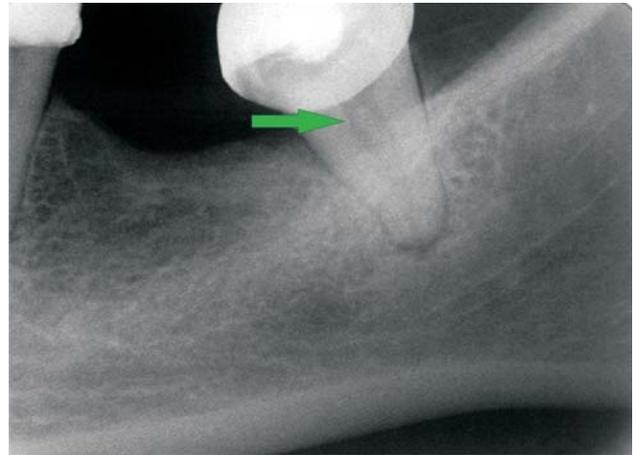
Retro-alveolar radiography of a 42-year-old patient with a large-sized denticle on the level of the 3.8 molar. It is also noticed the existence of a profound cavity process which seems to have evolved under the metallic covering crown which determined the apparition of a periapical lesion
